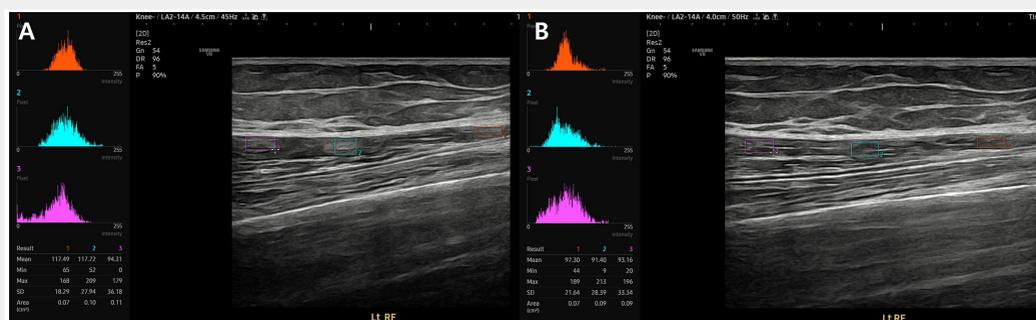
B-mode ultrasound images of the right quadriceps muscle before(A) and after(B) rESWT application. The histogram represents echo intensity, where black pixels have a value of 0, and bright white pixels have a value of 255. Higher echo intensity corresponds to a whiter pixel appearance. The echo intensity improved from 117.72 to 91.40 after 5 sessions of rESWT.
